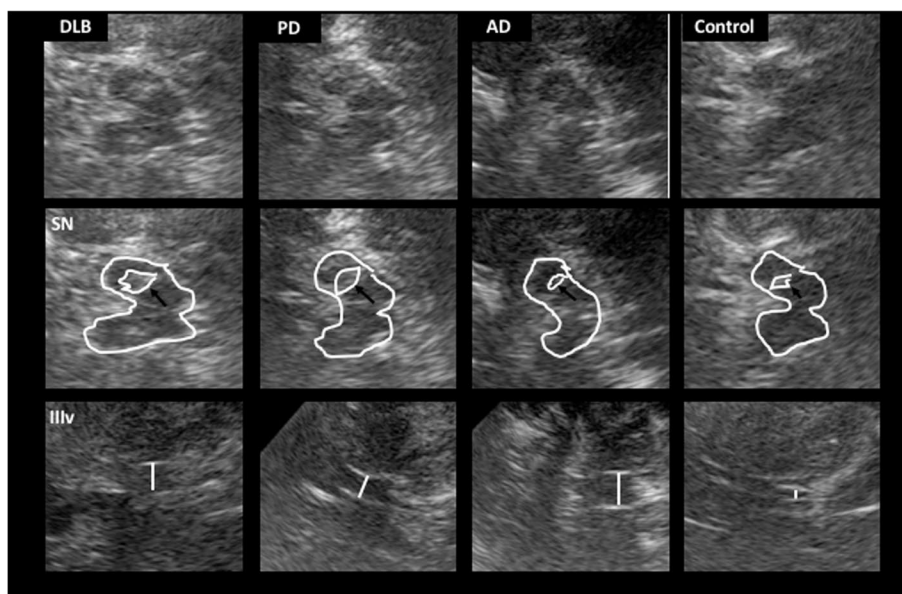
Sonographic images of mesencephalic and thalamic planes across study groups. Footnote: The figure shows ultrasound images of participants. Top row: raw images of the mesencephalic plane from patients with DLB, PD, AD and controls. Middle row: images of the mesencephalic plane, showing the perimeter of the mesencephalon (white external line) with the substantia nigra (SN) encircled (white internal line, black arrows). Bottom row: images of the thalamic plane, showing the size of the third ventricle (IIIv) (white line). The ultrasound findings include: SN hyperechogenicity and enlarged IIIv in a patient with DLB, SN hyperechogenicity with normal IIIv size in a patient with PD, normal echogenicity of the SN with enlarged IIIv in a patient with AD and normal SN echogenicity and normal IIIv size in a control subject
